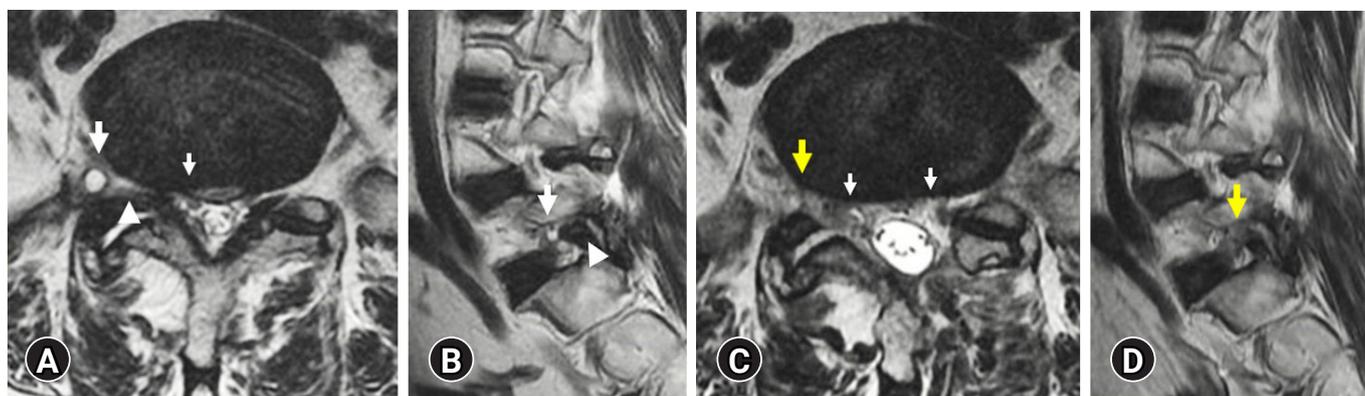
Left contralateral interlaminar endoscopic approach for the symptomatic extraforaminal juxtafacet cyst and foraminal and lateral recess stenosis in a 62-year-old woman presented with pain in the right buttock and radiating pain in both legs. (A, B) Preoperative magnetic resonance imaging (MRI) scans showing a juxtafacet cyst (bold white arrows) located in the cranial-ventral part of the extraforaminal space between the compressed exiting nerve root and the hypertrophied tip of the superior articular facet (SAP, white arrowheads) at the right side of the L5-S1 level. The S1 nerve root was also compressed by the coexisting lateral recess stenosis (thin white arrow). (C, D) Postoperative MRI scans revealing the successful removal of the contralateral (right) extraforaminal cyst (bold yellow arrows) and adequate decompression of coexisting contralateral foraminal stenosis including hypertrophied SAP and lateral recess stenosis (thin white arrows).
